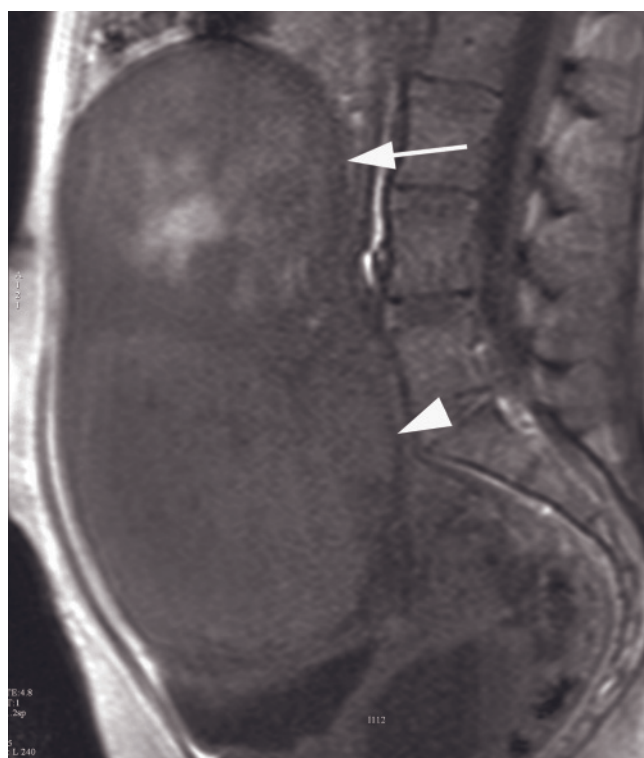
Multiple uterine leiomyomas before and after uterine artery embolization. Coronal T2-weighted SS-ETSE (a, b) and gadolinium-enhanced fat-suppressed T1-weighted gradient echo (c, d) and sagittal T1-weighted gradient echo (e, f) images. Images are obtained before (a, c, e) and after (b, d, f) uterine artery embolization (UAE). The large fibroids that show
